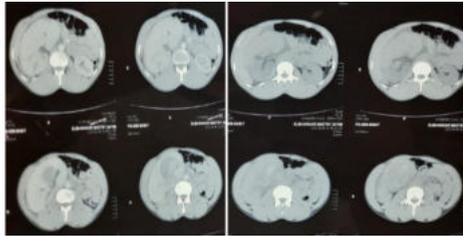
Axial sections of Computed Tomogram showing right renal angiomyolipoma with perinephric haematoma
